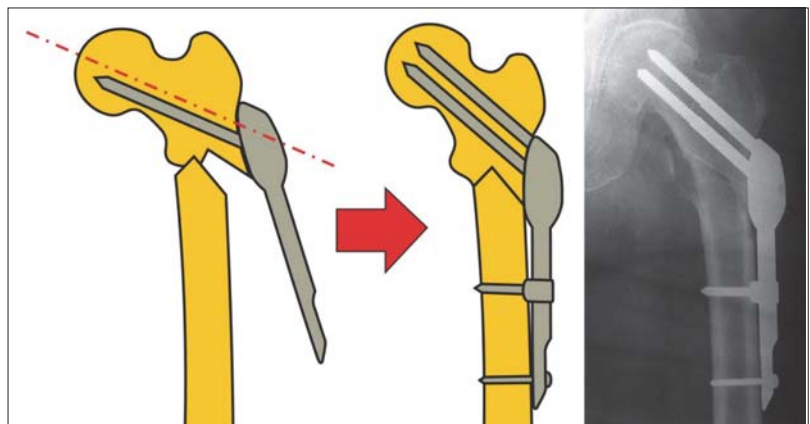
A scheme and an X-ray of subtrochanteric fracture reduction using the self-dynamisable internal fixator method; the first lag screw is positioned parallel to the femoral neck axis, and other screws are implanted after "joystick" reduction of the fracture and adjusting of the implant body position
